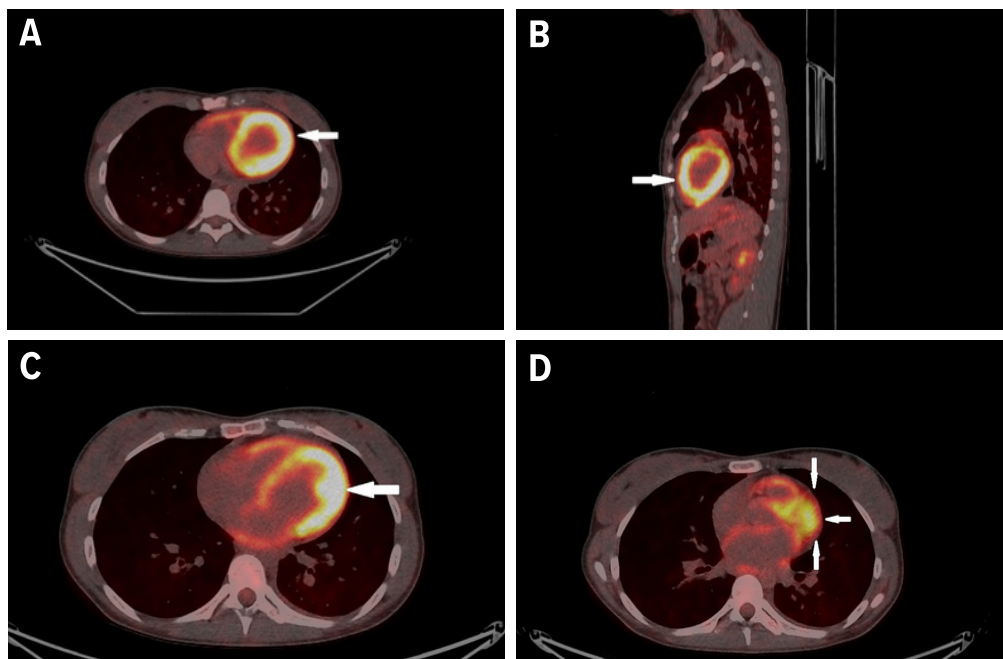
(A) The PET/CT image of the transversal section shows intense accumulation of FDG in the walls of the left ventricle and the septum (white arrow). (B) The PET/CT image of the sagittal section shows diffuse intense accumulation of FDG in the walls of the left ventricle (white arrow). (C) The PET/CT image of the transversal section shows focal left ventricular thickening, most likely corresponding to papillary muscle and less likely mural thrombus seen on CMRI septum (white arrow). (D) PET/CT image of the transversal section shows intense accumulation of FDG in the walls of the left atrium (white arrows).
